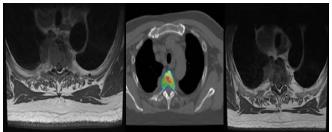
Imaging of a patient randomized to SBRT. Left: MRI pretreatment, Middle: Treatment dose plan on CT, Right: MRI evaluation 6 weeks after treatment
